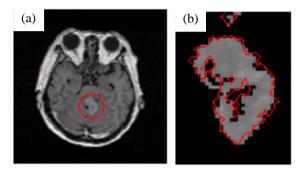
(a) MRIaxial slice with ROI encircled, and (b) Complete isolation of Tumor from MRI slice.
